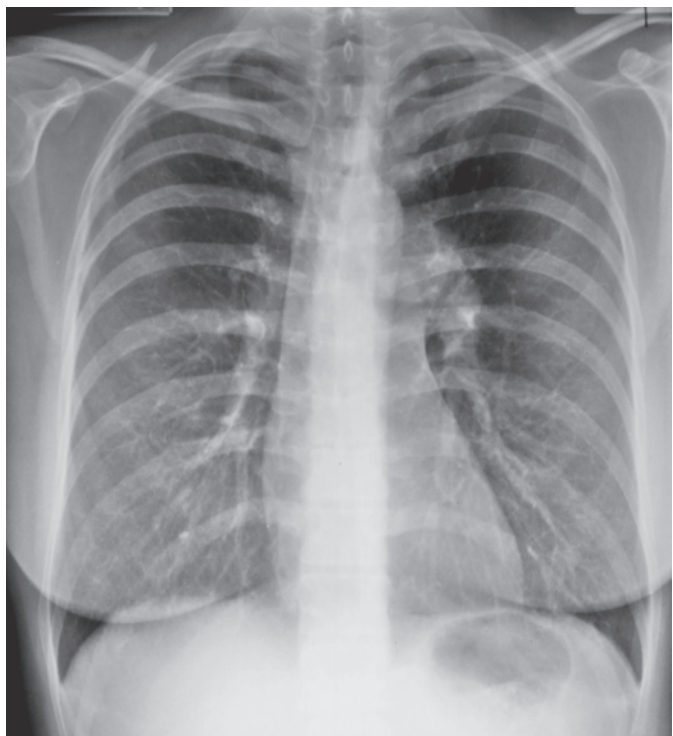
Typical chest radiograph from a patient with valvular pulmonary stenosis, showing normal cardiac size and marked prominence of main and left pulmonary arteries, representing poststenotic dilatation. This does not occur with infundibular pulmonary stenosis. Lung fields appear mildly oligemic.
